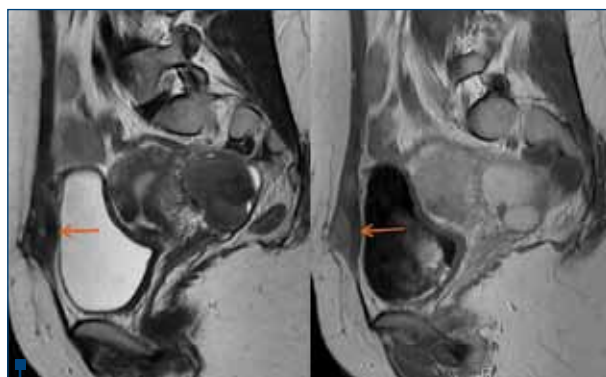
Pelvic MRI T1, T2: DIE STAGE III, ENZIAN 3B, Abdomino-pelvic wall endometriosis
